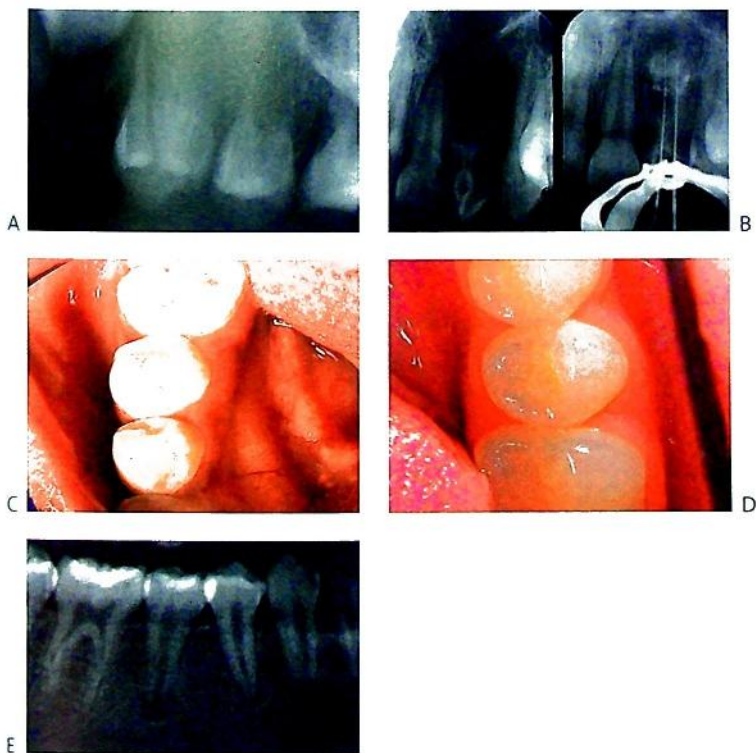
(A) Dens invaginatus in a maxillary first premolar tooth. (B) Ultimately, the prognosis is related to the ability to adequately instrument and obturate the canals of these teeth. Temporary endodontic dressings can be placed in such teeth to relieve symptoms and treat infection but it is almost impossible to obturate such canals. (C) Dens evaginatus. (D) Dens evaginatus where the tubercle has fractured off and the tooth has become necrotic. This child presented in acute pain with a facial cellulitis. The radiograph (E) shows the periapical area.
